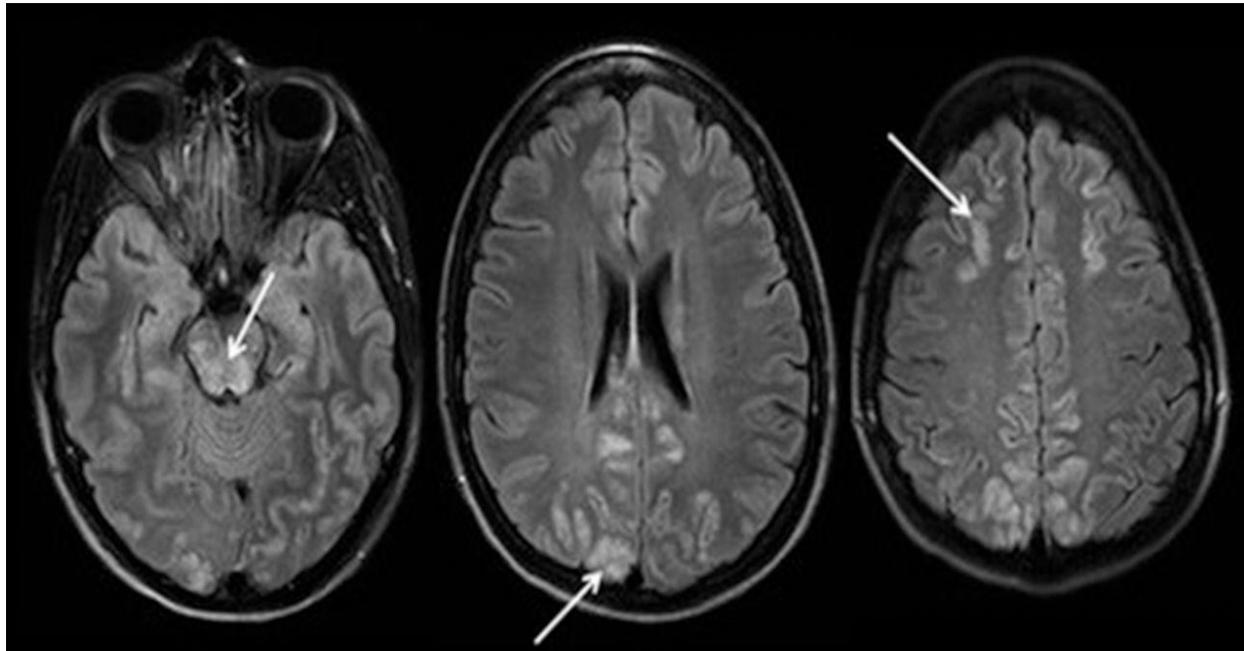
MRI image of a patient diagnosed with CKD 5, condition after surgery kidney transplant on the left from 07/19/2016 Recurrent nephropathy of the transplant Complication: Acute encephalopathy (PRES - syndrome of posterior reversible encephalopathy). MRI revealed diffuse lesions of the white matter of both hemispheres of the brain and areas of microischemia in the occipital lobe. Vasogenic edema in the parietal-occipital areas, as well as less common lesions in the frontal areas and brain stem
